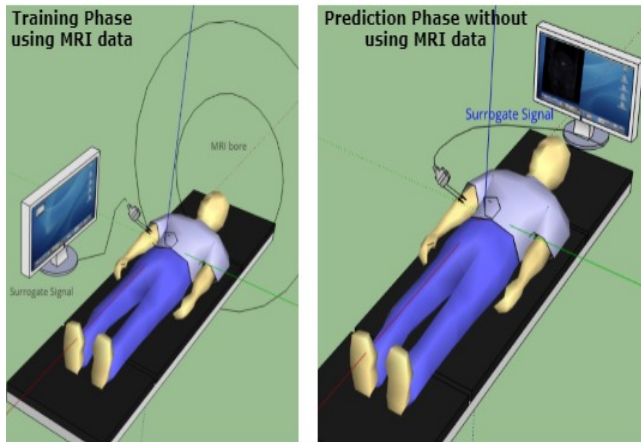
Overview of the experimental setup in training and prediction phase. While in the training phase, the model exploits MRI and surrogate data, in prediction phase only the surrogate signals are used to predict the motion estimate.
